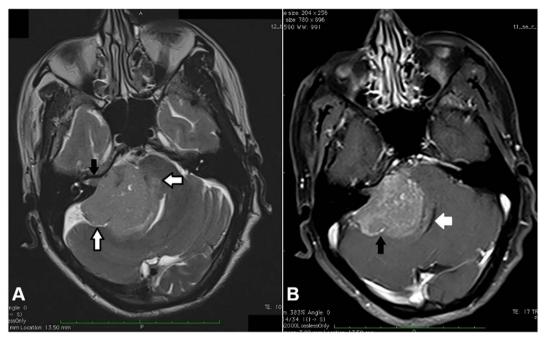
A) T2 weighted axial MRI image (Te: 109 ms, TR: 5830 ms) showing a lobulated heterogeneous extra axial right CP angle mass lesion (white arrows) extending in the right acoustic meatus (black arrow) and causing mass effect and effacement of the fourth ventricle. B) Post-contrast (Gadolinium) T1 weighted images showing heterogeneous enhancement in the right CP angle mass lesion (black arrow) with mass effect and compression of the fourth ventricle (white arrow).
